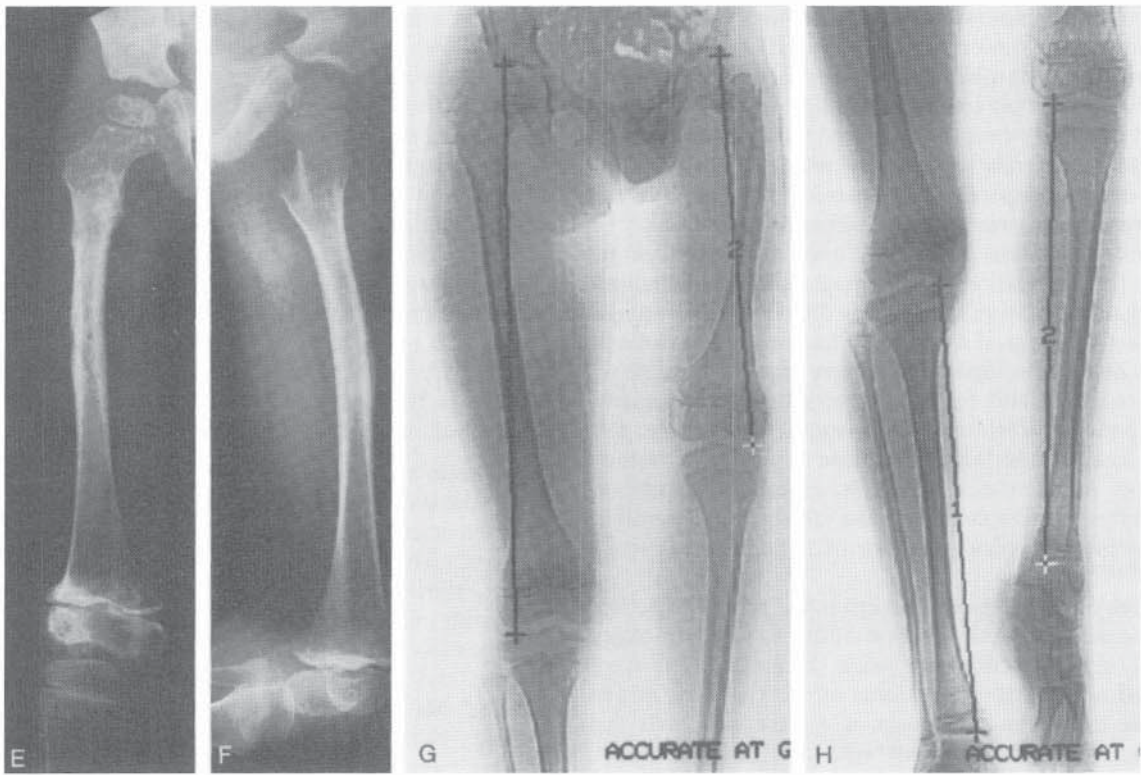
Continued.* E and F, Immediate postoperative radiographs. G and H, CT scan measurements show the marked lower limb length disparity due to postirradiation growth arrest of the proximal and distal femoral physes.
